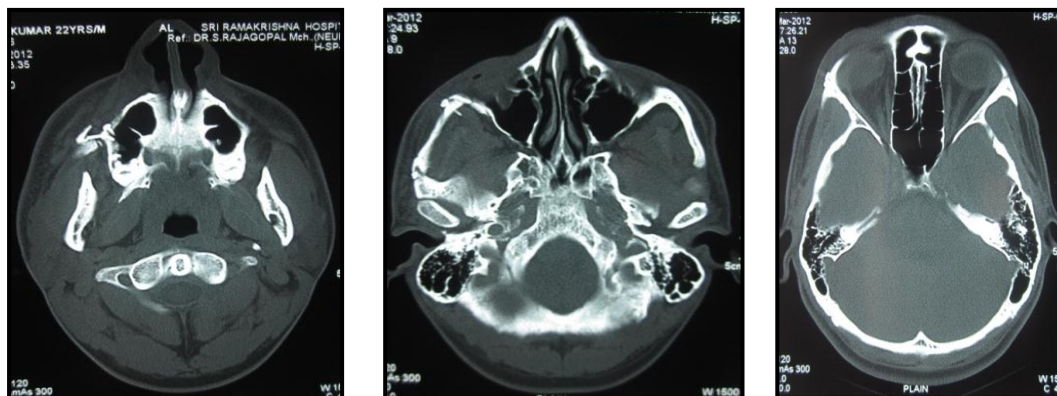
POST OPERATIVE CT SCANS
